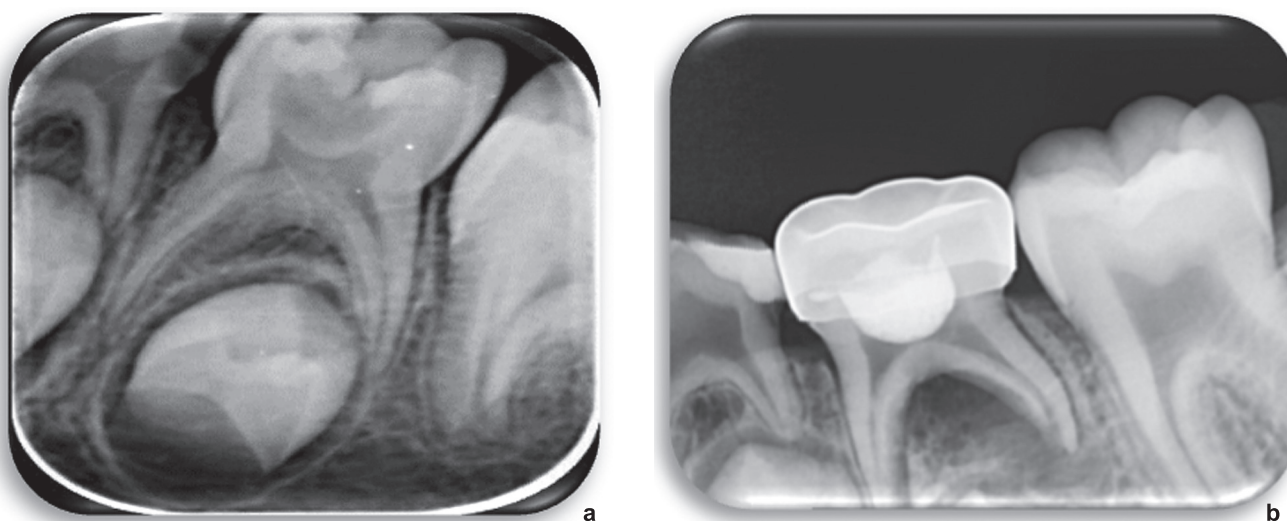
a – Preoperative periapical radiographs showing carious teeth. b – External resorption was seen in the 12th month control of the diode laser-treated tooth
